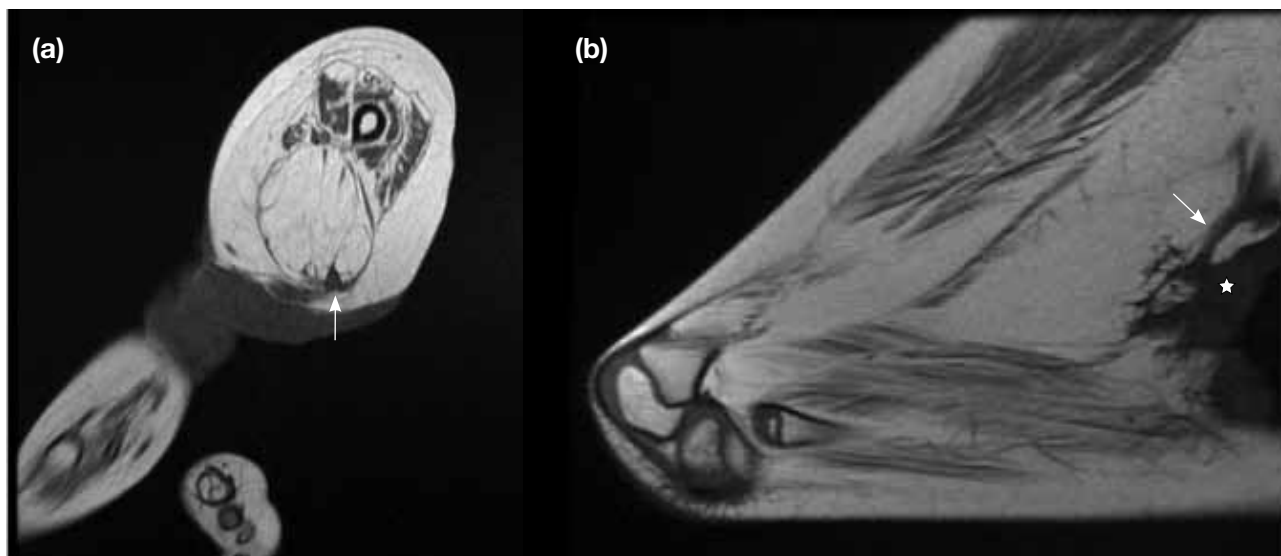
(a) Axial and (b) sagittal T1-weighted magnetic resonance images of the left knee showing the abnormal position of the peroneal nerve (arrows) abutting the anterior margin of pterygium band (*).
